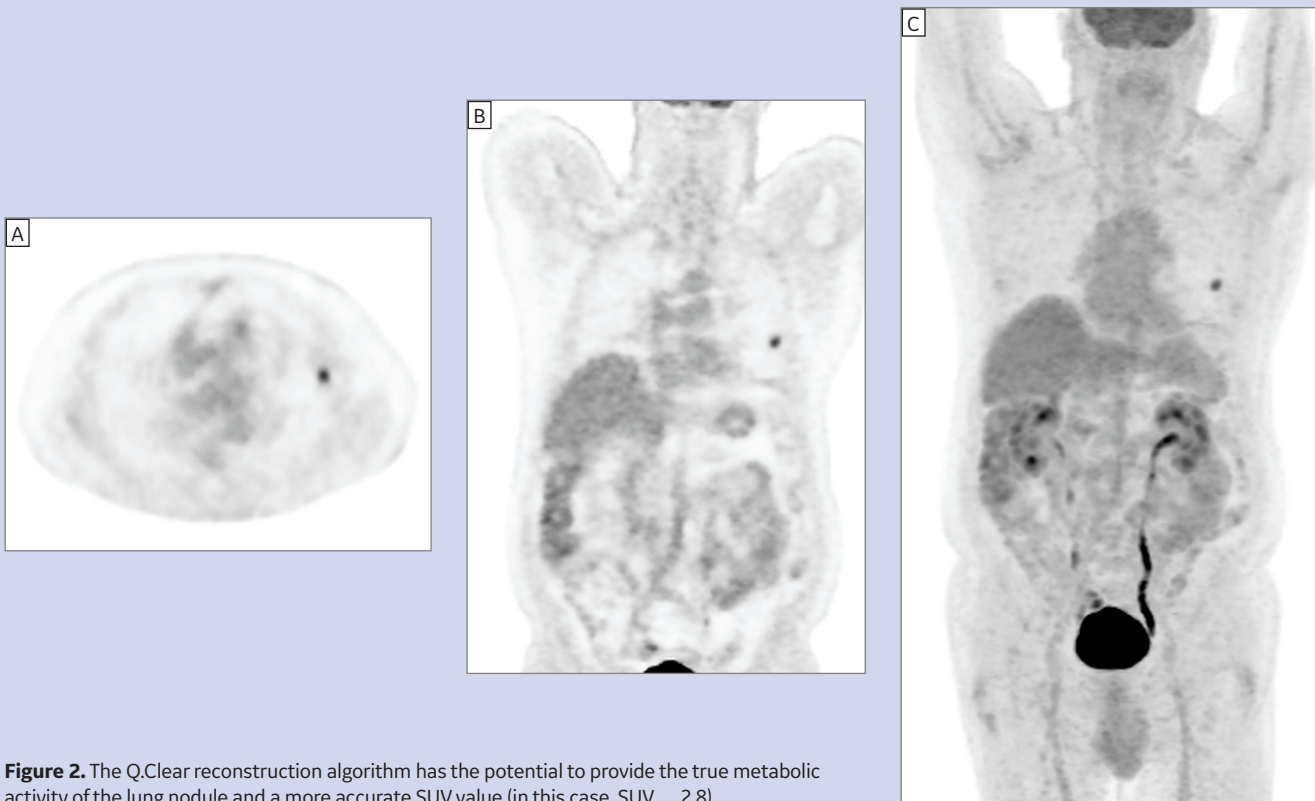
The Q.Clear reconstruction algorithm has the potential to provide the true metabolic activity of the lung nodule and a more accurate SUV value (in this case, SUV_{max} 2.8).
